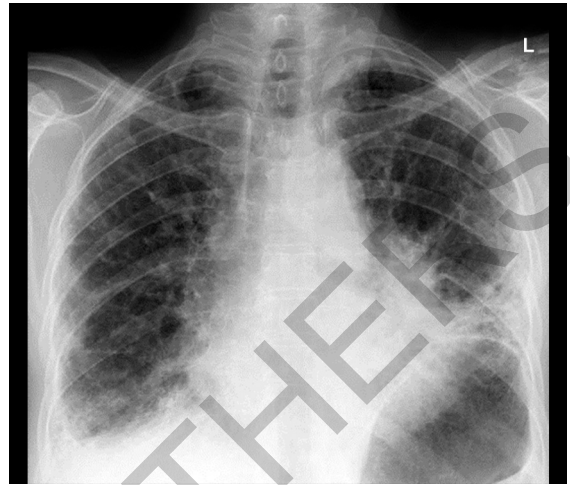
X-ray findings—peripheral markings are enlarged and white in color. The air-filled airways are seen as clear with dark straight shadows. The peripheral white markings are said to have the appearance of ground glass, representing affected alveolar spaces.
